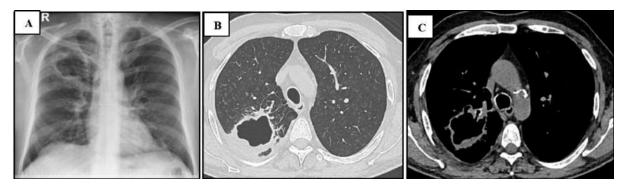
1A, Chest X-ray showing a thick-walled cavity in the right upper zone. 1B and 1C, CT Chest showing a thick wall cavity (1.4 cm) measuring  $5.8 \times 4.5 \text{ cm}$  in the right upper lobe with associated pleural thickening.
